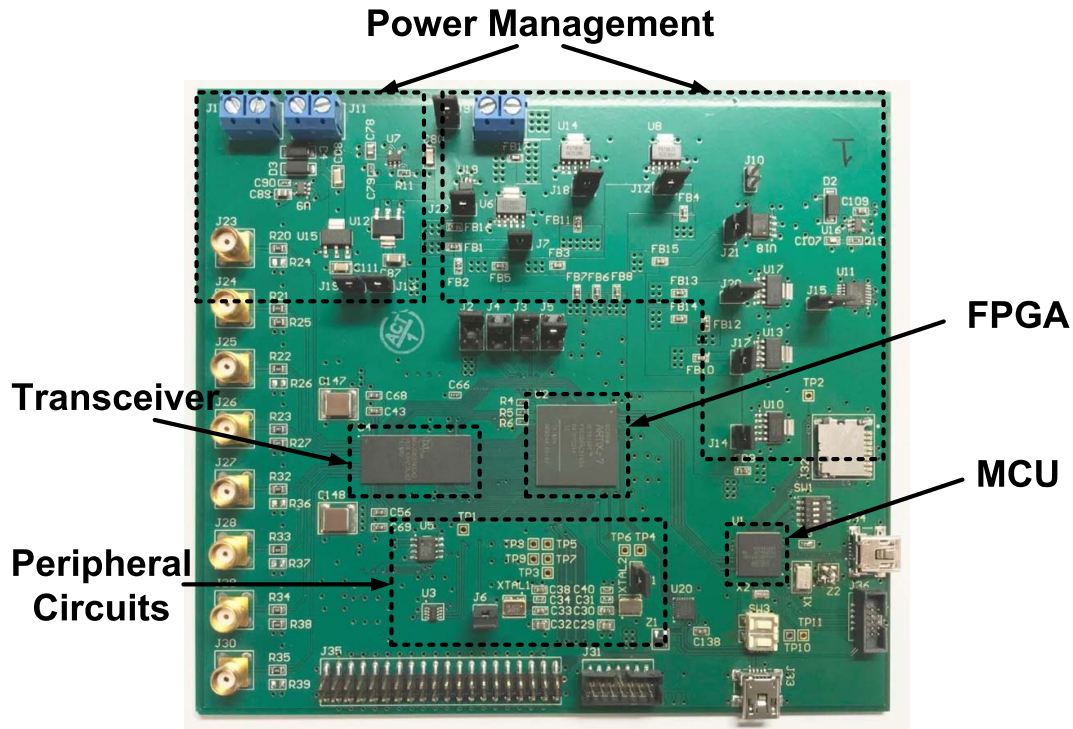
Designed portable ultrasound scanner system on a printed circuit board.
